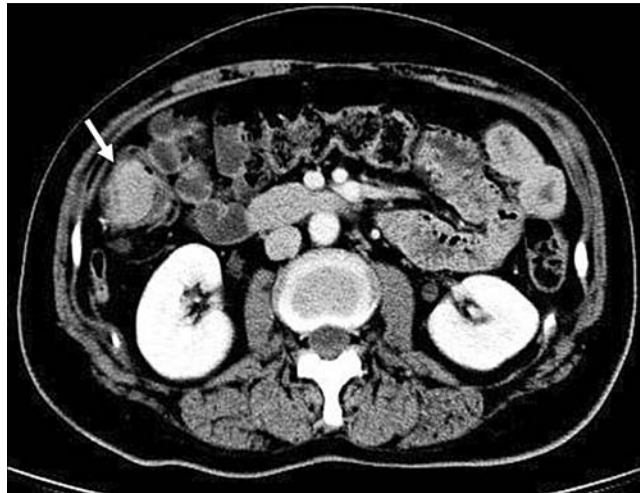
Abdominal computed tomography (CT) showed one mass (arrow) in the ascending colon.
